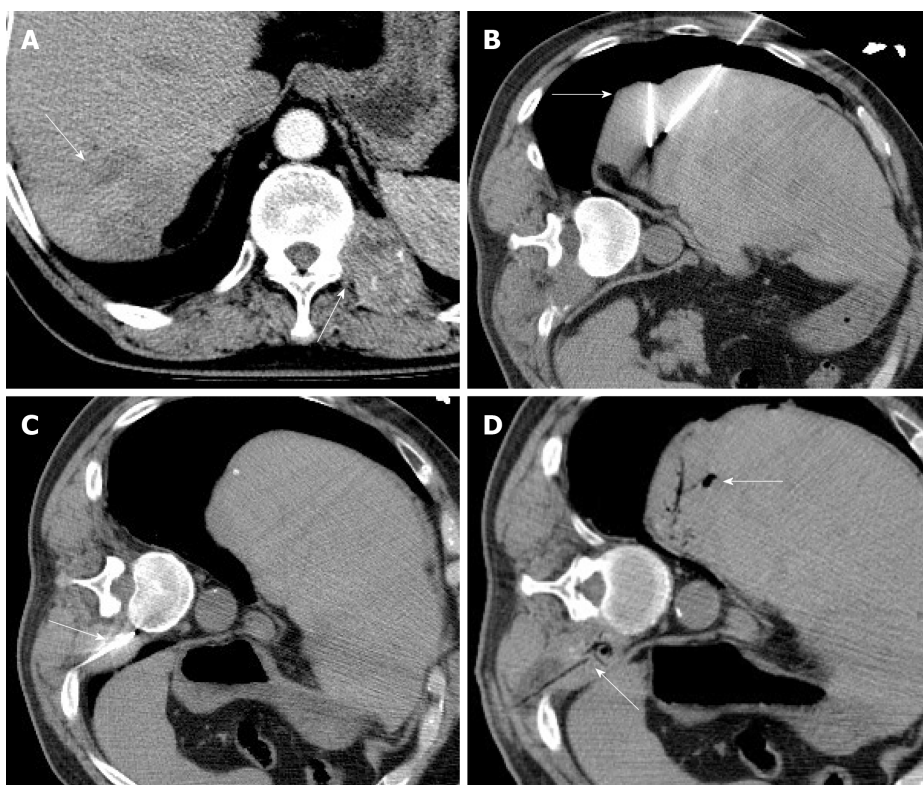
Computed tomography scan of the patient before and after argon-helium cryoablation. A: Multiple low-density round shadows of different sizes were noted (left arrow). Left hepatocellular carcinoma (HCC) metastasis of the 11th thoracic vertebra and vertebral arch plate, and bone structure damage (right arrow) were observed; B: Argon-helium cryoablation of the right posterior lobe of the liver; C: Argon-helium cryoablation of HCC metastases; D: Frozen necrosis gas and low-density hypovascular necrotic tissue were noted in the right posterior lobe (right arrow) and around the 11th lumbar spine (left arrow).
